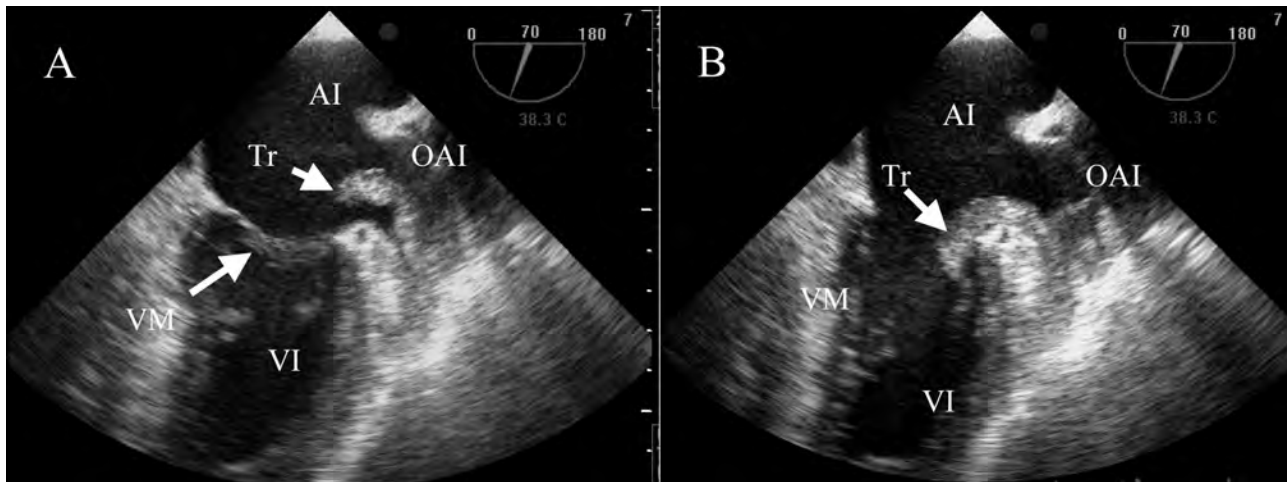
Transesophageal echocardiography. Panel A: Systole. Thrombus in the appendage which protrudes into the left atrium. Panel B: Diastole. The thrombus passed through the mitral ring and appears in the left ventricle. AI: left atrium; OAI: left atrium appendage; VI: left ventricle; Tr: thrombus. VM: mitral valve.
